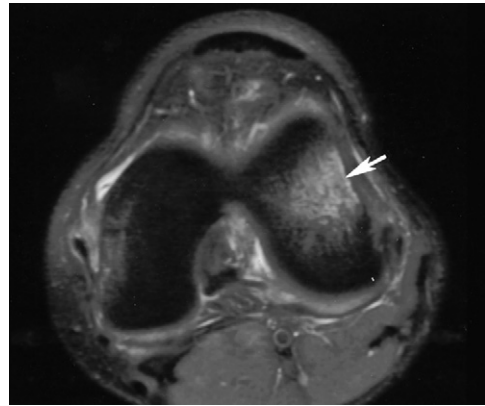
Fat-suppressed fast spin-echo T2-weighted image demonstrates a bone bruise in the lateral femoral condyle (arrow).
